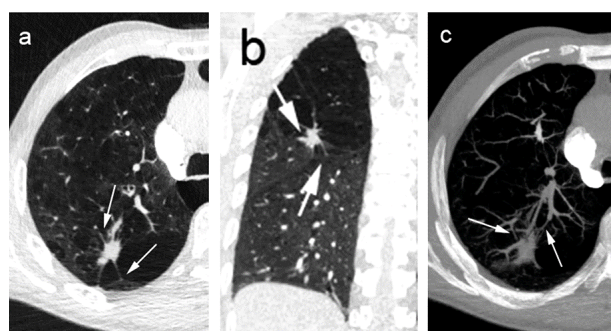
CT characteristics of a 62-year-old male patient with poorly differentiated adenocarcinoma of the right upper lobe. (a) CT plain scan showed that the lesion showed solid density and was about 19.6×10.3 mm in size. The spicule, lobulation and pleural traction signs (arrows) can be seen at the margin of the lesion, and emphysema changes can also be observed. (b) Sagittal position showed that the interlobar pleura was pulled and displaced, and the lobulation sign can be seen in the margin of the lesion (arrow). (c) The tumor vascular sign (arrow) was observed after the MIP recombination (arrow).
